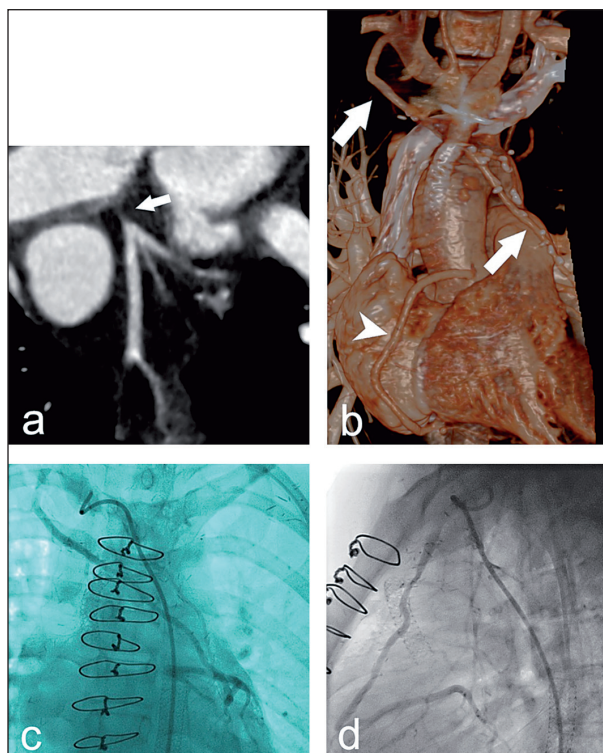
a) Coronary CT angiography, multiplanar reformation. Subocclusive stenosis (lesion) of left main (LM) coronary artery (arrow). b) Coronary artery bypass graft (arrows): right internal mamarian artery (RIMA) revascularizing left anterior descending (LAD) and obtuse marginal (OM) arteries. Normal right coronary artery (arrowhead). c) Coronary angiography of the LM coronary artery bypass with RIMA to the circumflex artery. Normal coronary perfusion after intervention. d) Coronary angiography, lateral view.
